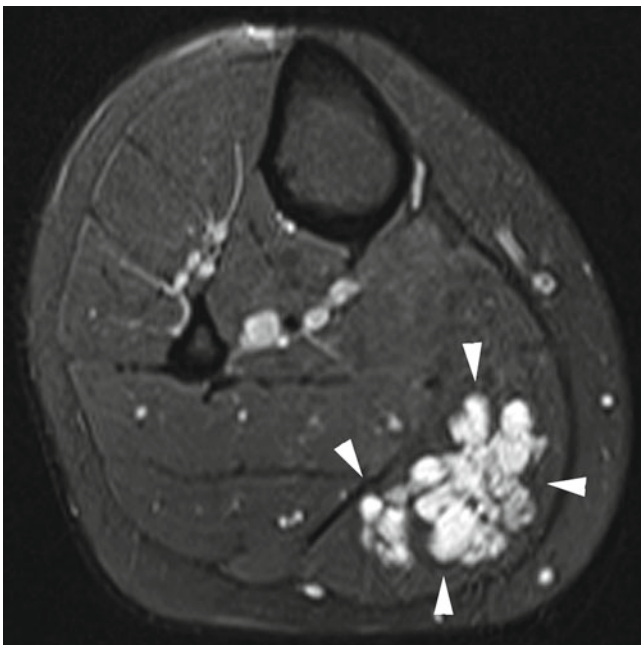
Fat saturated transverse MR image in a patient with a slow-flow venous malformation (*arrowheads*) inside the medial gastrocnemius muscle. High signal intensity fluid-filled venous caverns are demonstrated
